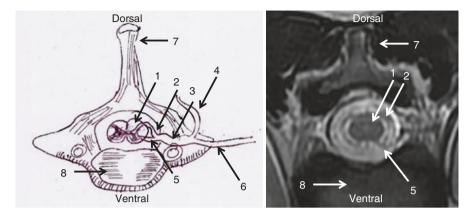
Anatomy of the spinal cord, nerve root and vertebral body. Cross sectional (*axial*) view of the spine showing a sketch (*left*) and MRI T2-weighted image (*right*) revealing: (*1*) spinal cord (posterior columns); (2) dorsal root and dorsal root ganglion; (3) spinal nerve; (4) posterior primary ramus (continues to innervate paraspinal muscles); (5) ventral root; (6) anterior primary ramus (continues to form plexus); (7) vertebral spinous process; (8) vertebral body and intervertebral cartilaginous disc
